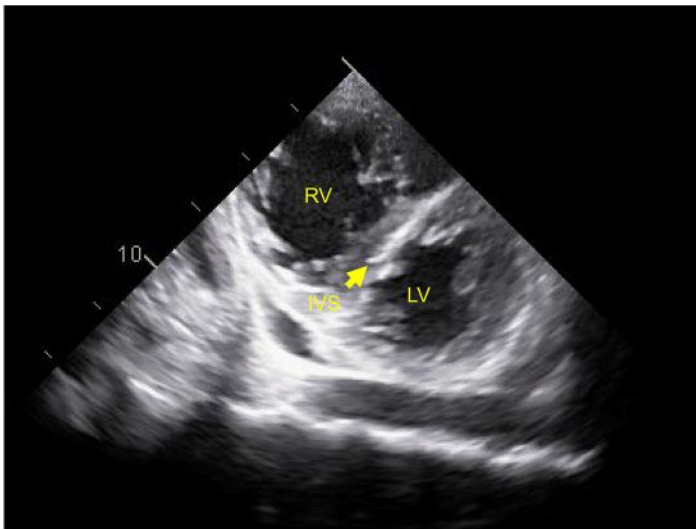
Parasternal short-axis view from a TTE demonstrating a “D-shaped” septum in a patient with severe PAH and RVF. IVS, intraventricular septum.
